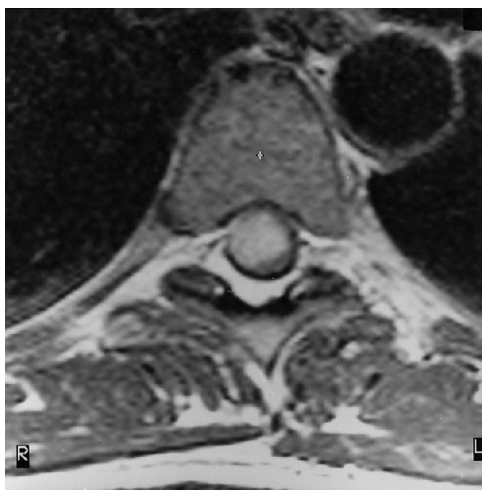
Axial T1-weighted image (450/30/4) at T-6 after contrast administration shows the tumor involves the right anterolateral part of the cord.
